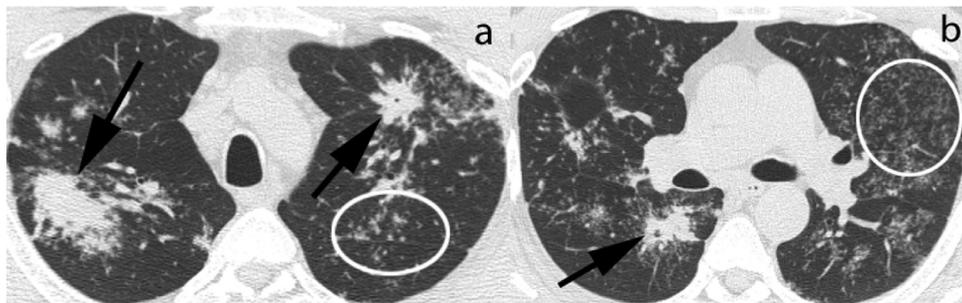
(a, b) CT showing nodular consolidation (arrows) and small nodules (ovals) in the perilymphatic distribution. CT, computed tomography.
